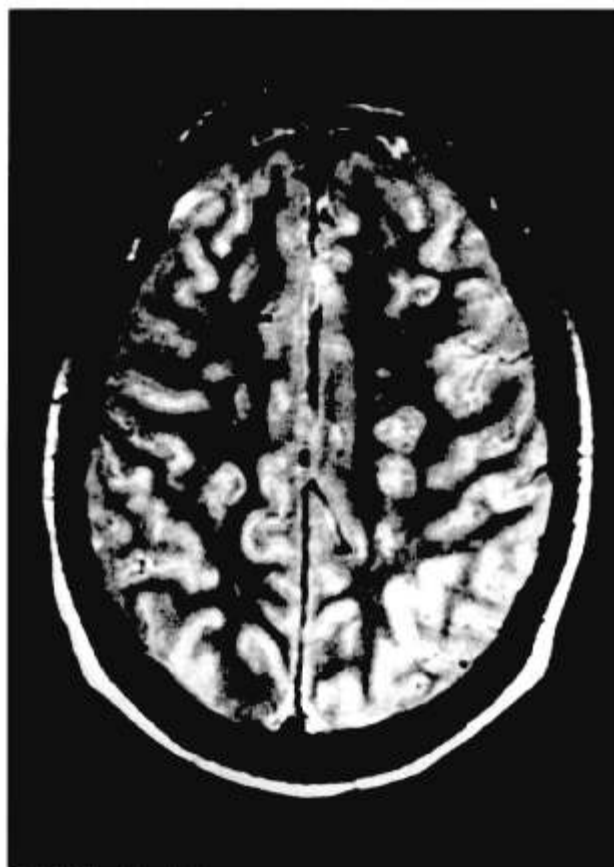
T₂-weighted MRI scan of the brain. Frontal and temporo-occipital hyperintense lesions in the periventricular
